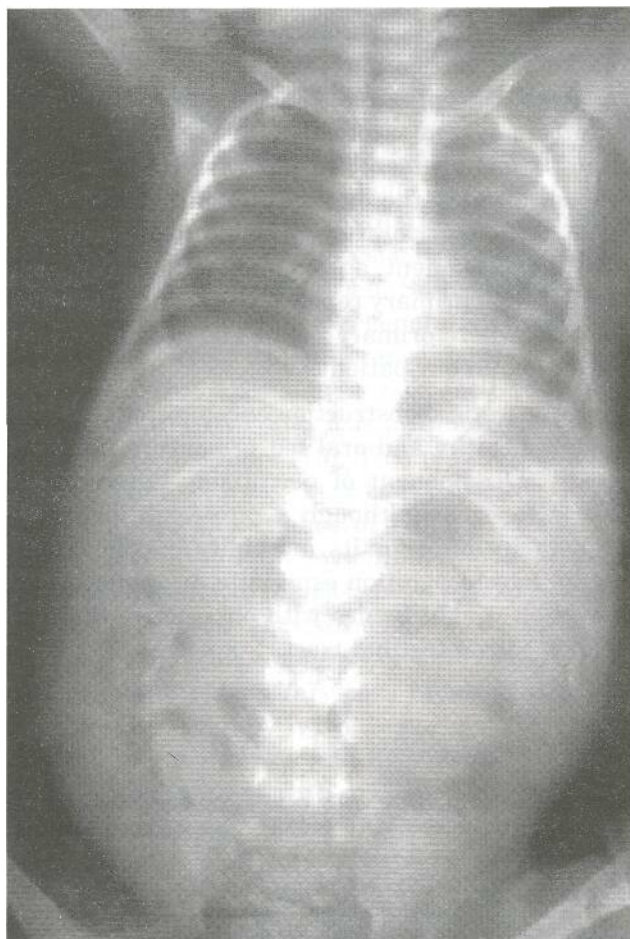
Plain abdominal radiography showed a marked decline in the abdominal gas extent and soap bubble appearance in the lower right quadrant
